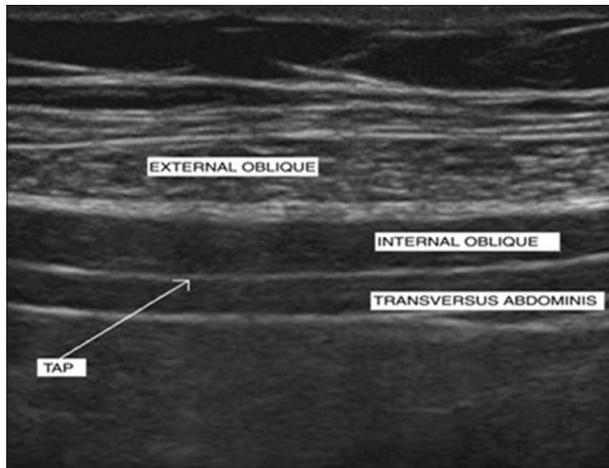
Ultrasound-guided picture of transversus abdominis plane
